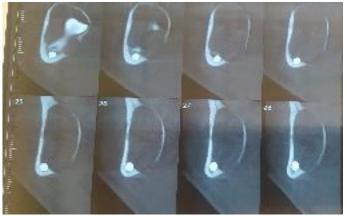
a: computed tomography in Coronal view showing a wide unilocular oval cystic lesion of the left hemimandible: The lesion pushing the mandibular canal towards the basilar border with a localized interruption of the lingual cortical
